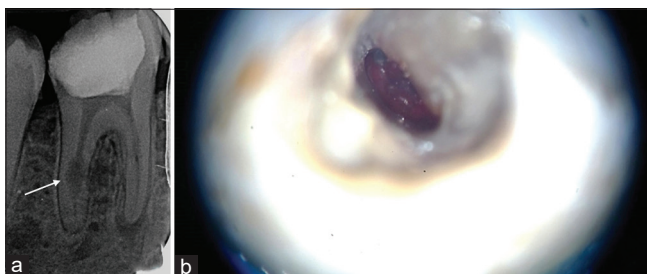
(a) Preoperative radiograph showing internal perforation defect (white arrow) along with the presence of periradicular lesion at the site of internal perforation. (b) Magnified image of the bleeding from the perforation site inside the distal canal
